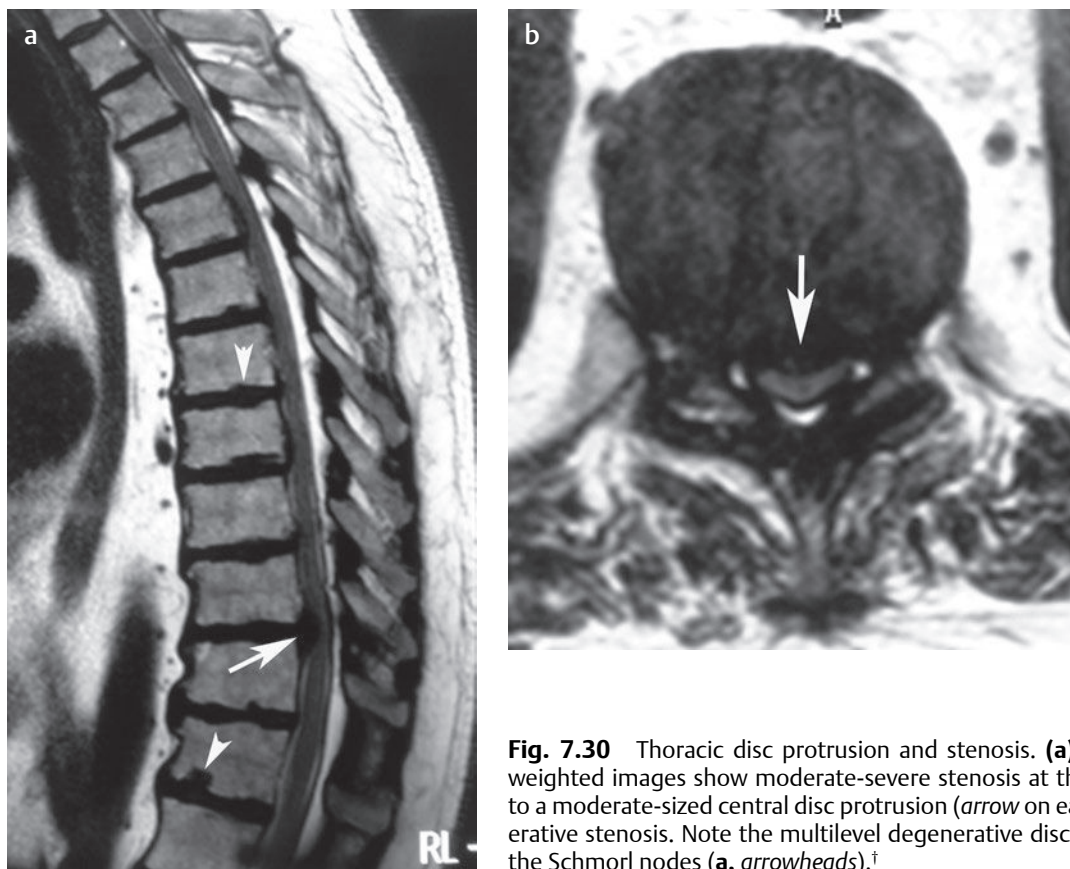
Thoracic disc protrusion and stenosis. (a) Sagittal and (b) axial T2-weighted images show moderate-severe stenosis at the T10-T11 level secondary to a moderate-sized central disc protrusion (arrow on each) and underlying degenerative stenosis. Note the multilevel degenerative disc disease at other levels and the Schmorl nodes (a, arrowheads).[†]
